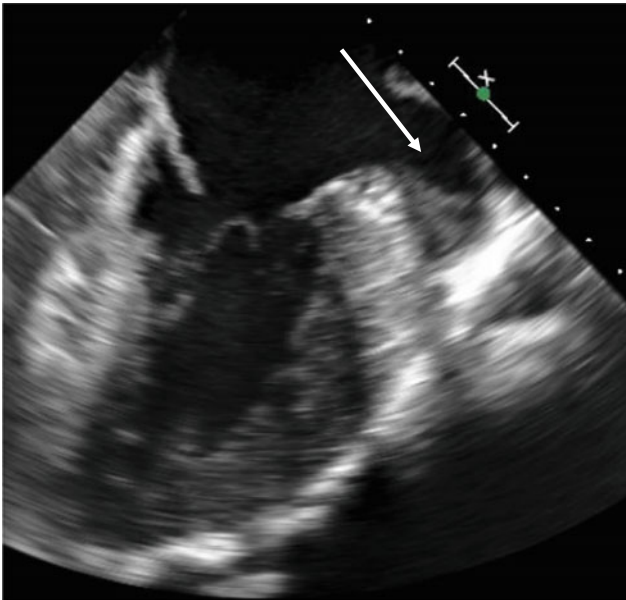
Thrombus in a patient with cardiac amyloidosis and atrial flutter. Two-chamber view on transesophageal echocardiography demonstrating thrombus within the left atrial appendage (arrow) (August 2018)
